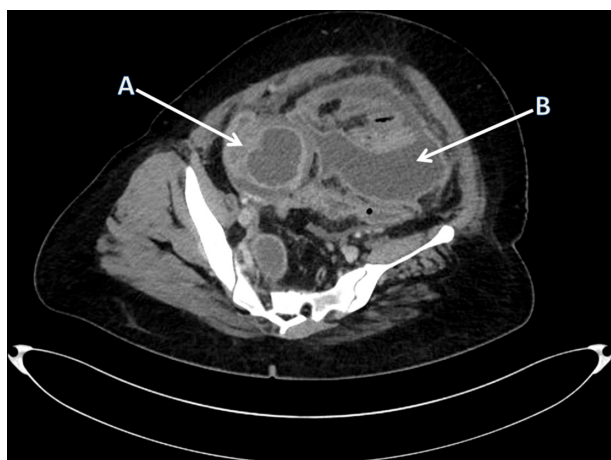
CT image (coronal section) showing A: right tubo-ovarian mass, B: pelvic collection, C: mesenteric lymph nodes and D: abdominal free fluid.
